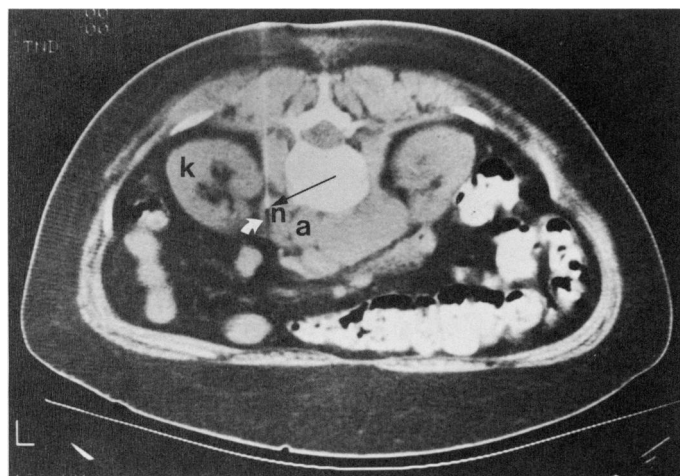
Metastatic cervical carcinoma. CT scan demonstrating needle tip (black arrow) in para-aortic lymph node (n). Note that in this prone patient the access route avoids the kidney (k) and aorta (a). Curved white arrow shows a needle-tip artifact.
